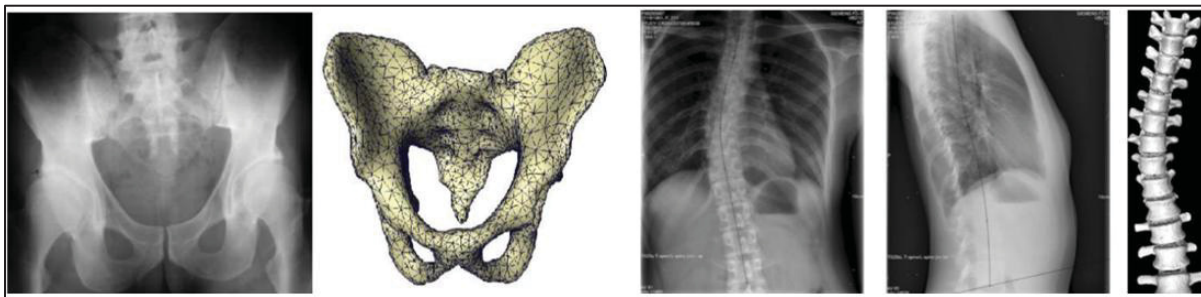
3D reconstruction of pelvis from one X-ray image and Spine from two biplanar X-ray images
